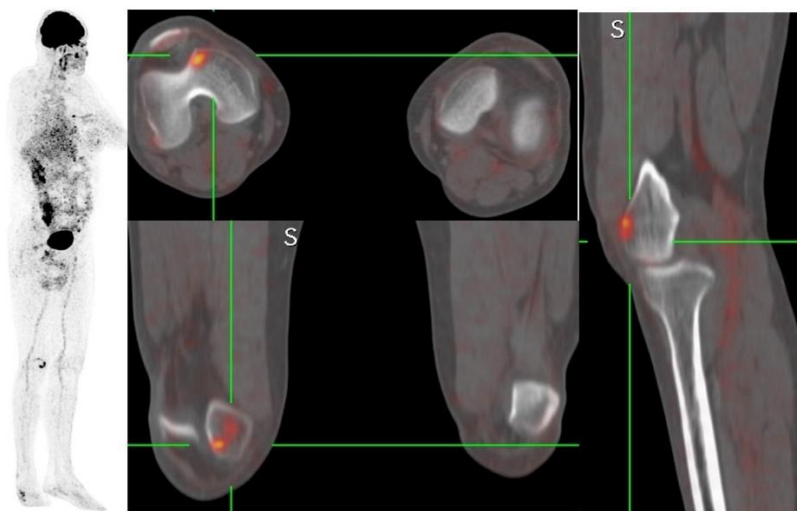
The patient with single pathologic lesion at the distal diaphysis of right femur (outside the routine imaging field); 68 years old male patient referred for restaging; Multiple intensity projection, transaxial, sagittal and horizontal slices of fusion PET/CT images, respectively
